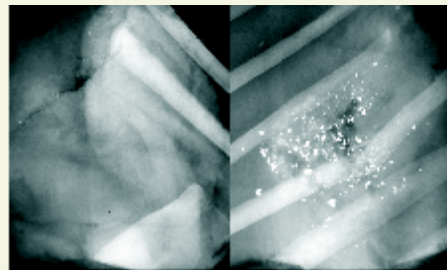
X-ray of lead particles on edges of “arrow wound”.
